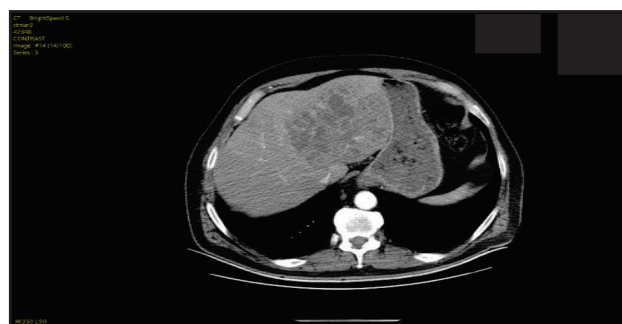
CT-scan of the liver abscess
